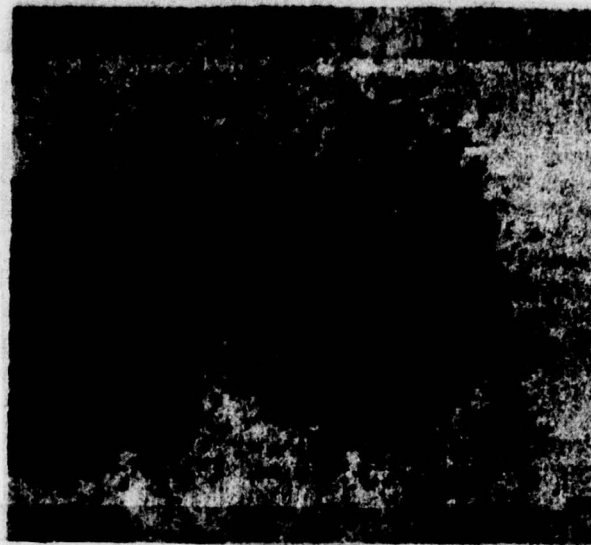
Ventilation scintigram (PA). Impairment of lung ventilation in patient with obstructive emphysema.
